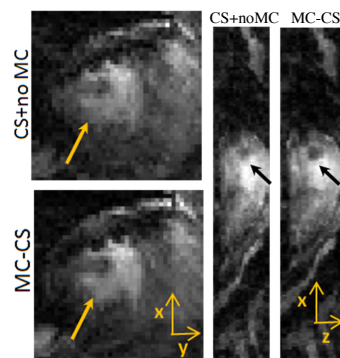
In-vivo 3D free breathing CINE MRI: 3D reconstructed cardiac frames without (CS+no MC) and with motion correction (MC-CS). MC-CS images have better delineation of the boundary of myocardium compared to CS+no MC.
